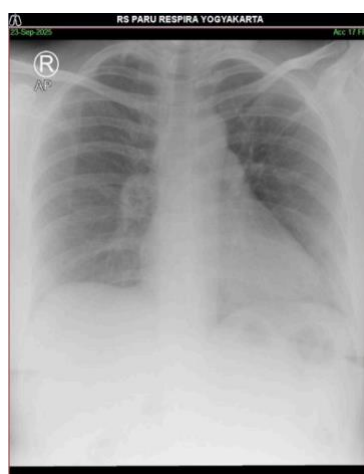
Chest Radiography Findings in Acute Asthma Exacerbation
